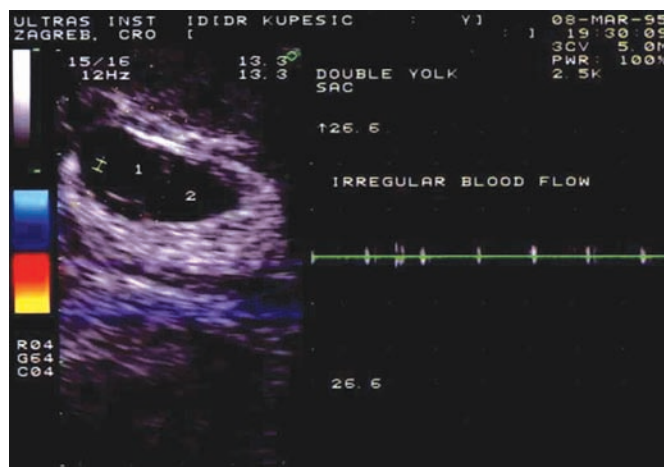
A transvaginal color Doppler scan of a gestational sac containing a double yolk sac with irregular blood flow signals.
